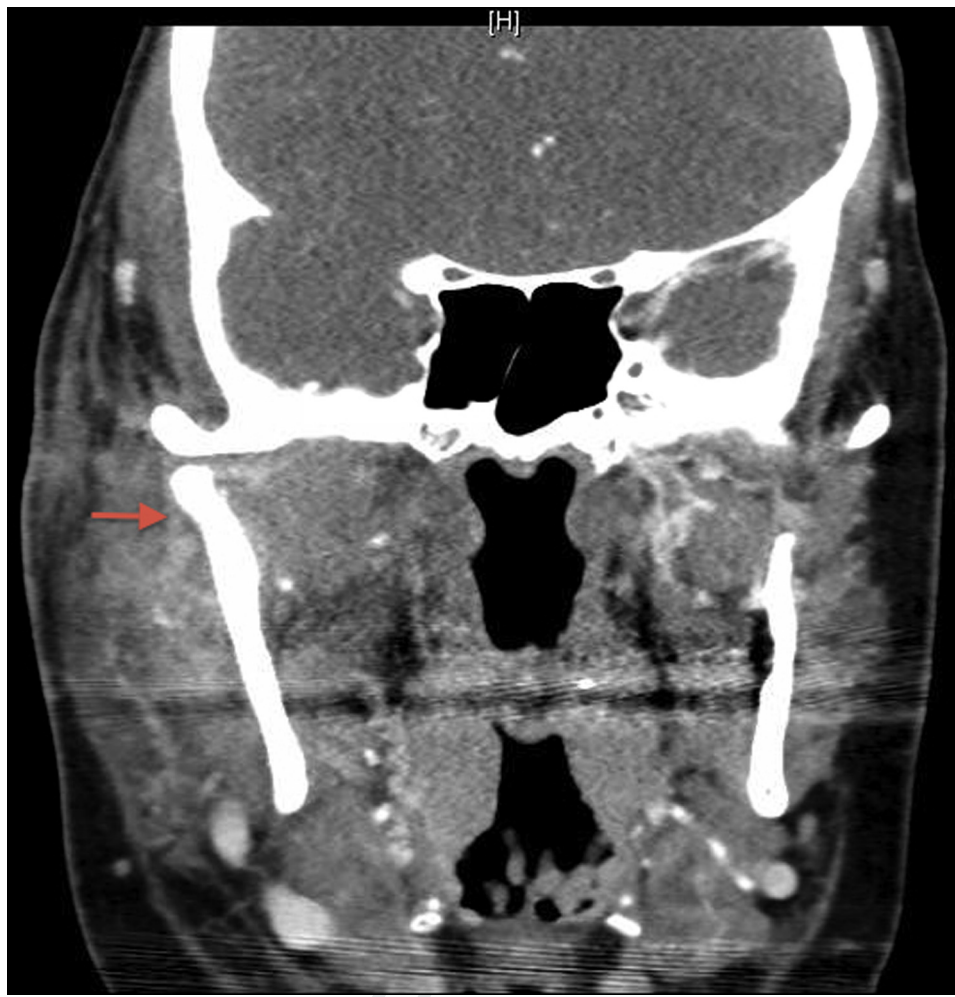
Case 2. Preoperative maxillofacial contrast-enhanced coronal computed tomogram on day 49 displays a periosteal submasseteric abscess (arrow) at the mandibular ramus communicating with the temporomandibular joint.
